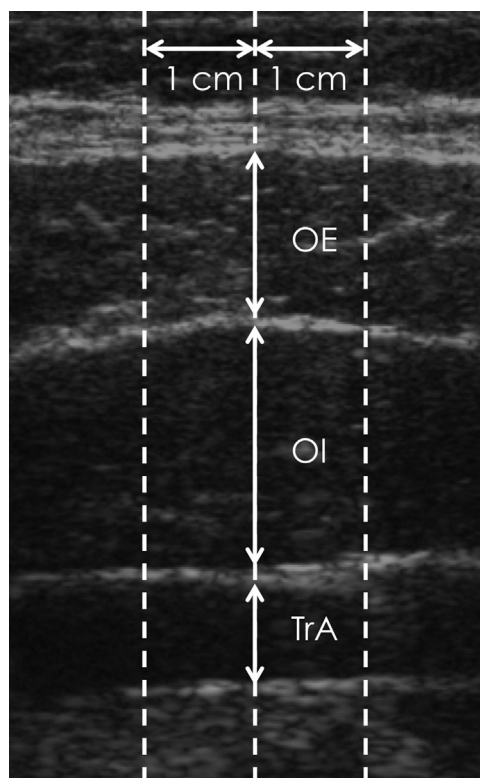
Measurement of muscle thickness from ultrasound imaging. Measurements of the thickness of transversus abdominis (TrA), obliquus internus abdominis (OI), obliquus externus abdominis (OE) were made in the middle of the image and at 1-cm intervals on either side.
